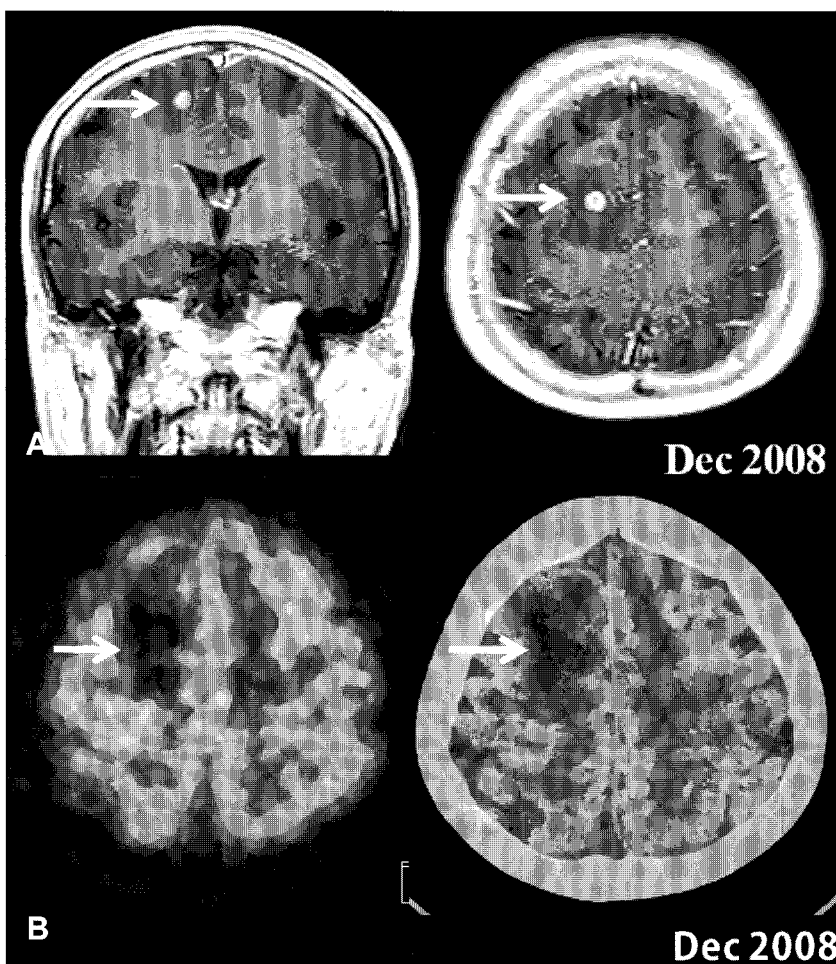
After 4 months, the patient presented with a progressively worsening symptoms of the central nervous system. (A) A MRI was performed for evaluation of cerebral metastasis and a enhanced nodule, measured less than 1cm (arrow), was observed in right frontal lobe. It was followed immediately by (B) an F-18 FDG PET/CT scan and it showed markedly decreased FDG uptake associated with vasogenic edema in right frontal lobe. Even at the time of this FDG PET/CT scan, the cerebral metastasis revealed only hypometabolic lesion and metastatic lesion with increased FDG uptake was not seen. It has been recognized that common malignant tumors that metastasize to the brain are lung cancer, colorectal cancer, melanoma, and breast cancer in sequence.¹⁾ Most of the metastatic brain tumors from lung cancers are hypermetabolic, however, they could be iso-, or hypometabolic on FDG-PET.^{2,3)} Although this case revealed hypometabolic cerebral metastasis from NSCLC, metastatic brain tumors from NSCLC was more frequently hypermetabolic than those of small cell lung cancer (SCLC).²⁾ Even though lesion size has been suggested as a false negative factor in detection of cerebral metastasis at FDG-PET,⁴⁾ biological characteristics such as expression of GLUTs and hexokinase activity of tumors are important for FDG accumulation in a brain lesion.^{5,6)} In a previous study, the main mechanism of glucose uptake in SCLC cell lines was via the expression of GLUT-1 and GLUT-3, which might be ineffective for FDG uptake in brain metastatic lesions.⁷⁾ To clarify the cerebral metastasis from NSCLC, a further study is necessary to draw a more definite explanation about the mechanism of a low FDG uptake in metastatic brain tumors from NSCLC.
